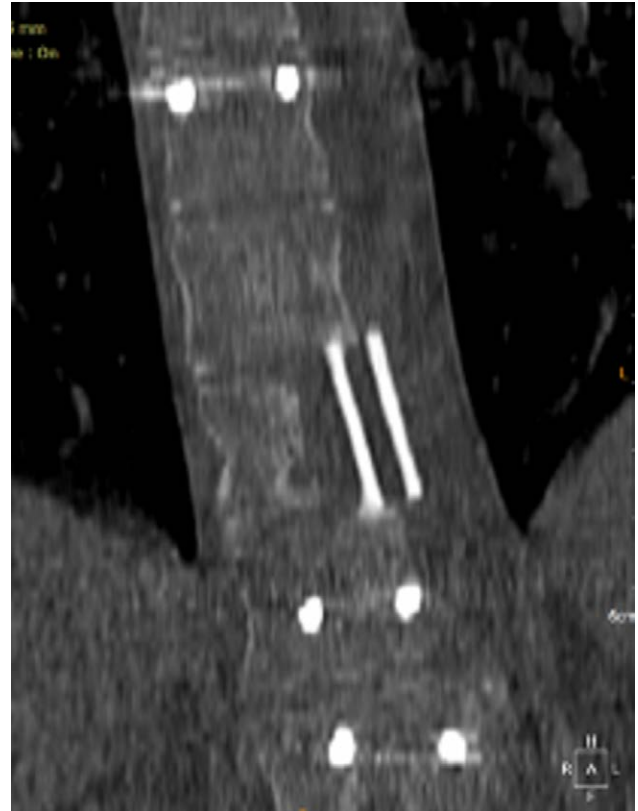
CT scan evaluation 3 months postoperative (note the bony union).
